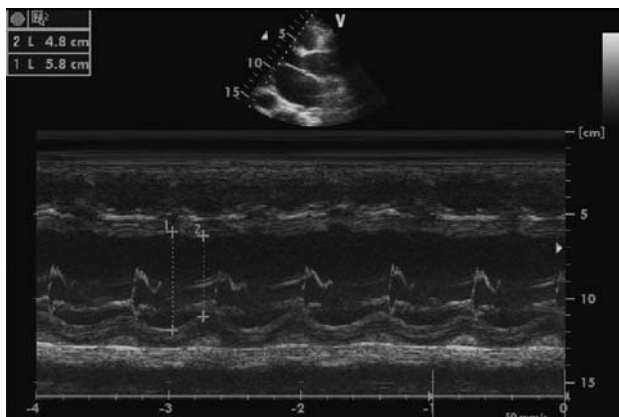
Left ventricle end-systolic and end-diastolic diameter measurement in the transthoracic M-mode echocardiography of the case presented.
